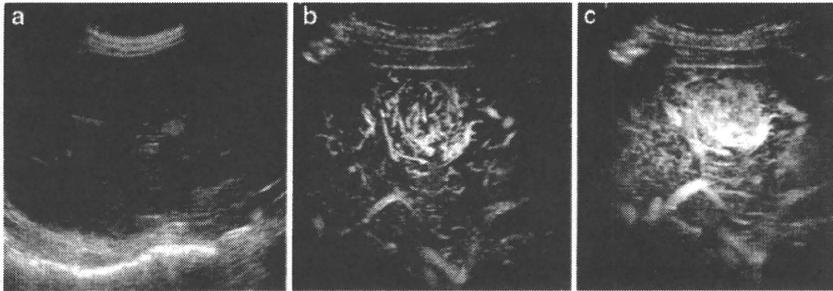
Contrast-enhanced ultrasound. (a) Baseline sonogram shows a focal hypoechoic HCC. (b) In the early arterial phase, there is hypervascularity with dysmorphism of the visualized tumor vessels. (c) At the peak of arterial phase, the lesion is very bright compared with the surrounding liver.
